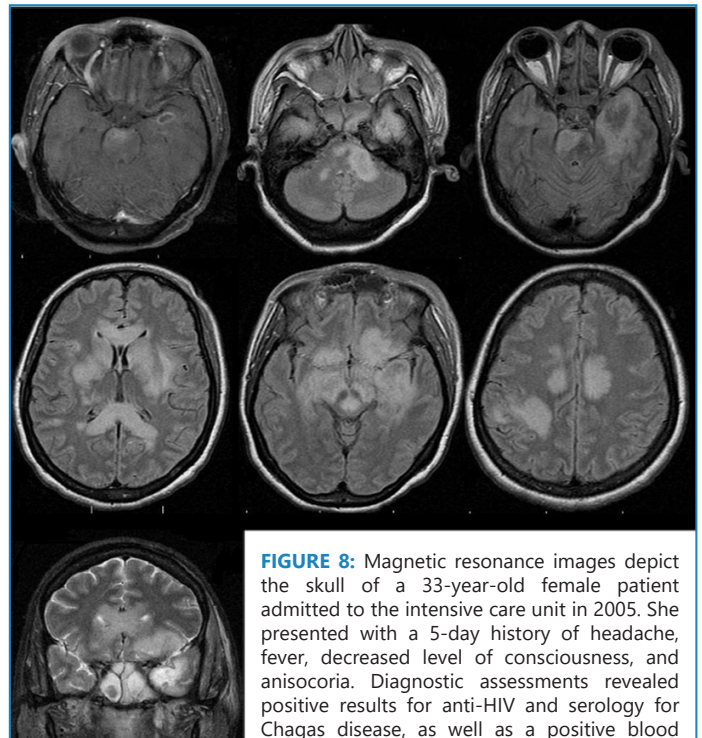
Magnetic resonance images depict the skull of a 33-year-old female patient admitted to the intensive care unit in 2005. She presented with a 5-day history of headache, fever, decreased level of consciousness, and anisocoria. Diagnostic assessments revealed positive results for anti-HIV and serology for Chagas disease, as well as a positive blood culture for *T. cruzi*. Cerebrospinal fluid analysis showed 10 cells per mm³, with 92% of lymphocytes, proteins at 78, and glucose at 40 mg/dl, along with the presence of numerous forms of *T. cruzi*. Immunological parameters indicated CD4 at 26 mm³ and HIV Viral Load at 1,160,000 copies.
